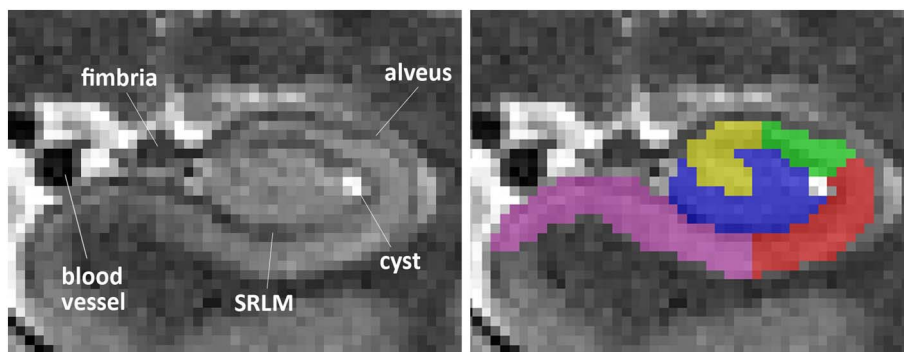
Structures excluded from segmentation in a coronal view. Anterior hippocampal body slice from a T2 MRI scan including alveus, fimbria, SRLM, a blood vessel and a cyst in the ventrolateral flexion point of CA1 in the vestigial hippocampal sulcus.
